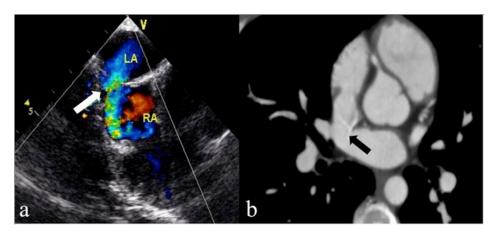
(a)Transesophageal echocardiography shows the sinus venosus type atrial septal defect and left to right shunt (white arrow)(LA: left atrium, RA: right atrium), (b) Axial CT image demonstrates the sinus venosus type atrial septal defect (black arrow)
